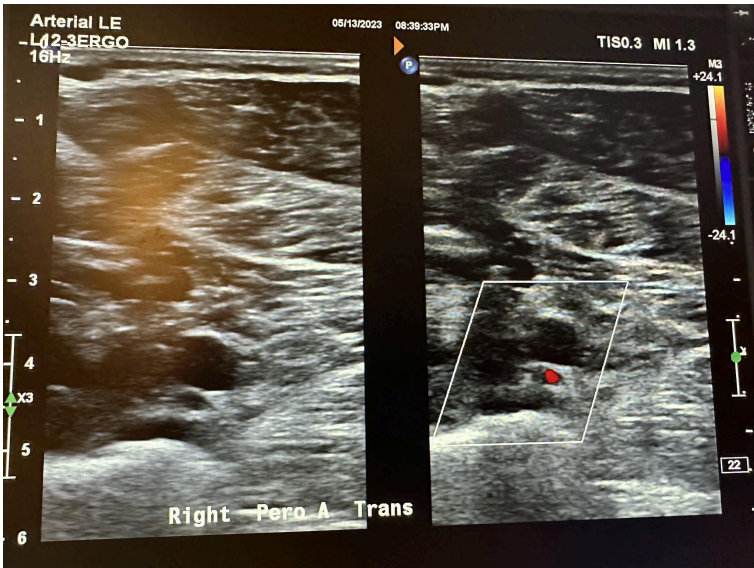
Side-by-side transverse images of the right peroneal artery without color Doppler and with color Doppler.
